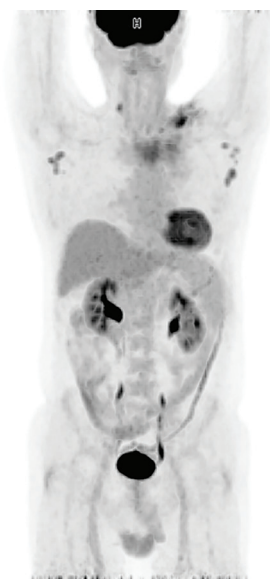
MIP image of the second PET/CT. Right cervical, bilateral axillary, left supraclavicular and lesion in the left pectoral muscle suspicious for metastasis. MIP: Maximum intensity projection, PET/CT: Positron emission tomography/computed tomography
